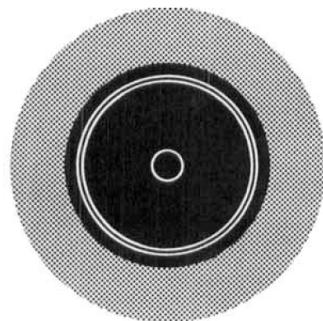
The ultrasonic layers of the rectum. The transducer lies centrally. 1st layer, echogenic, mucosa; 2nd layer, echopoor, muscularis mucosae; 3rd layer, echogenic, submucosa; 4th layer, echopoor, muscularis propria; 5th layer, echogenic, serosa/perirectal fat
